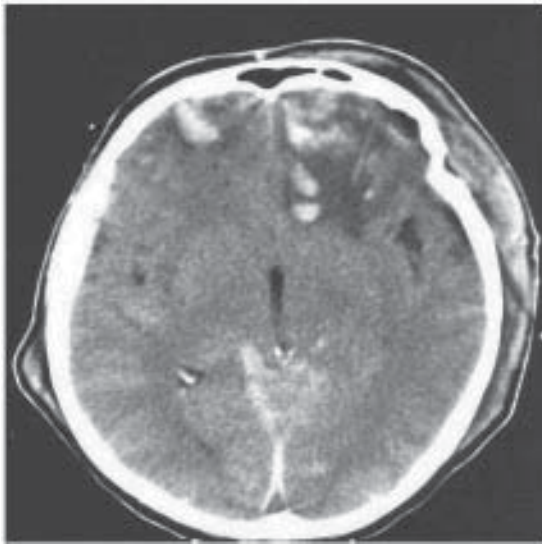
Computed tomography of head of a patient with bifrontal contusions.
